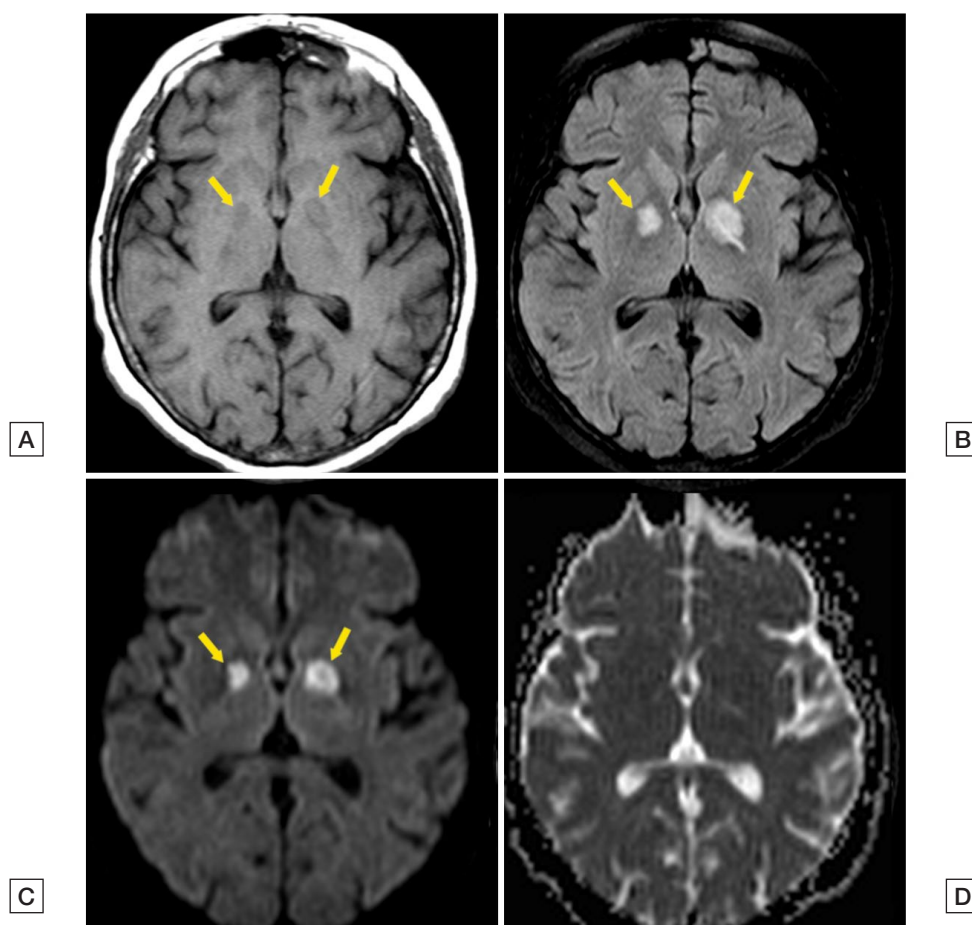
MRI shows [A] T1-weighted bilateral hypointensity, with [B] T2-FLAIR hyperintensity, and [C-D] restricted diffusion in globus pallidus.
